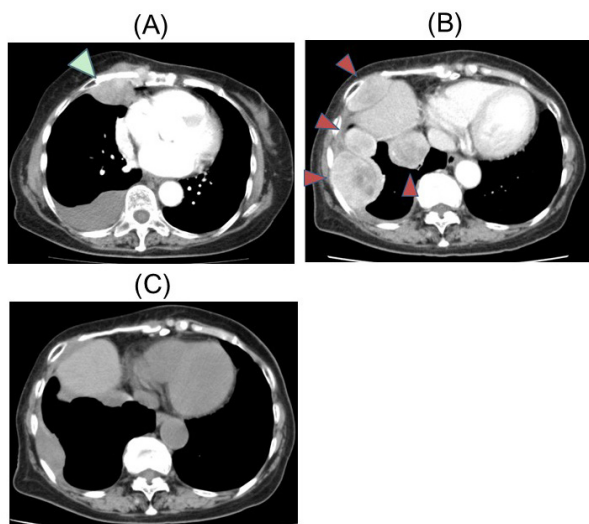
Computed tomography images of the chest. (A) Right pleural effusion and a lobular mass (white arrowhead) were observed at the initial examination. (B) Multiple masses on the right pleura (red arrowheads) appeared 5 months after the operation. (C) Regressed masses on the pleura after 4 courses of chemotherapy.
